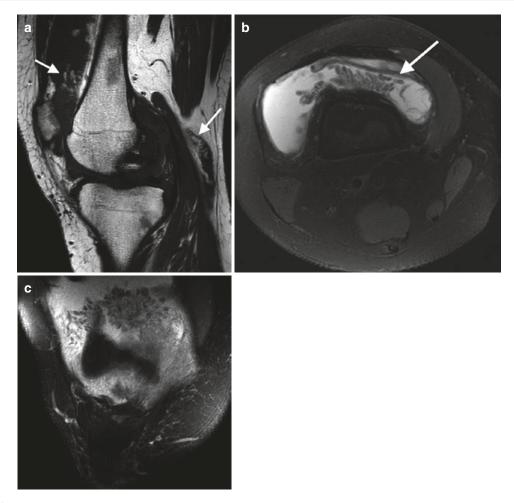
Lipoma arborescens, 51-year-old female with recurrent knee effusions. (a) Saggital T1 MRI demonstrating fat fronds with the suprapatellar recess and within a Baker's cyst (*arrows*). (b) Axial T2FS fronds are low
